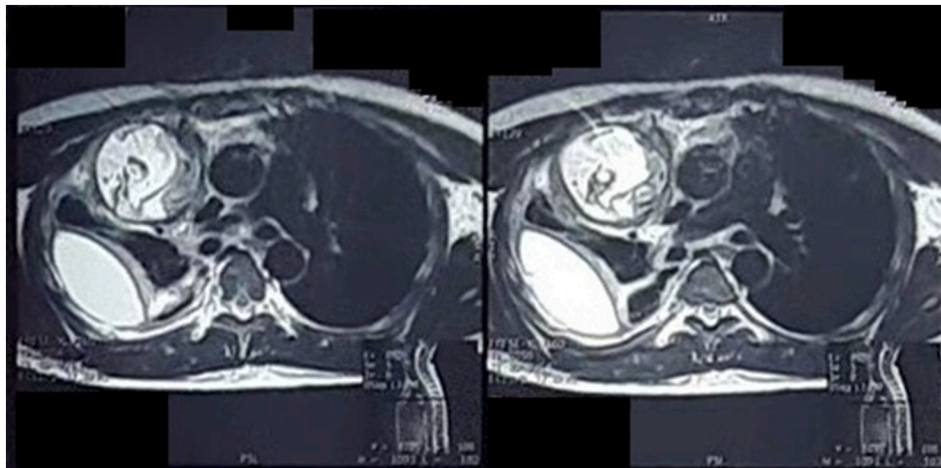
Thoracic MRI showed a solid mass ($5.7 \times 7.7 \times 8.7$ cm) with cysts and fat component, peritumoral bleeding, and Loculated pleural effusion in the right lobe.
